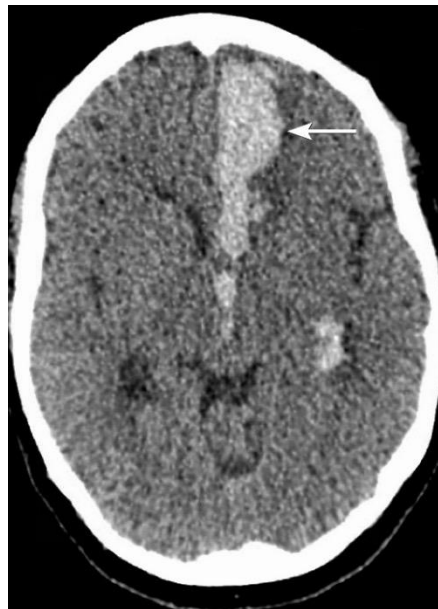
CT brain shows subarachnoid along the interhemispheric fissure (white arrow) with extension into the third and left lateral ventricle.
